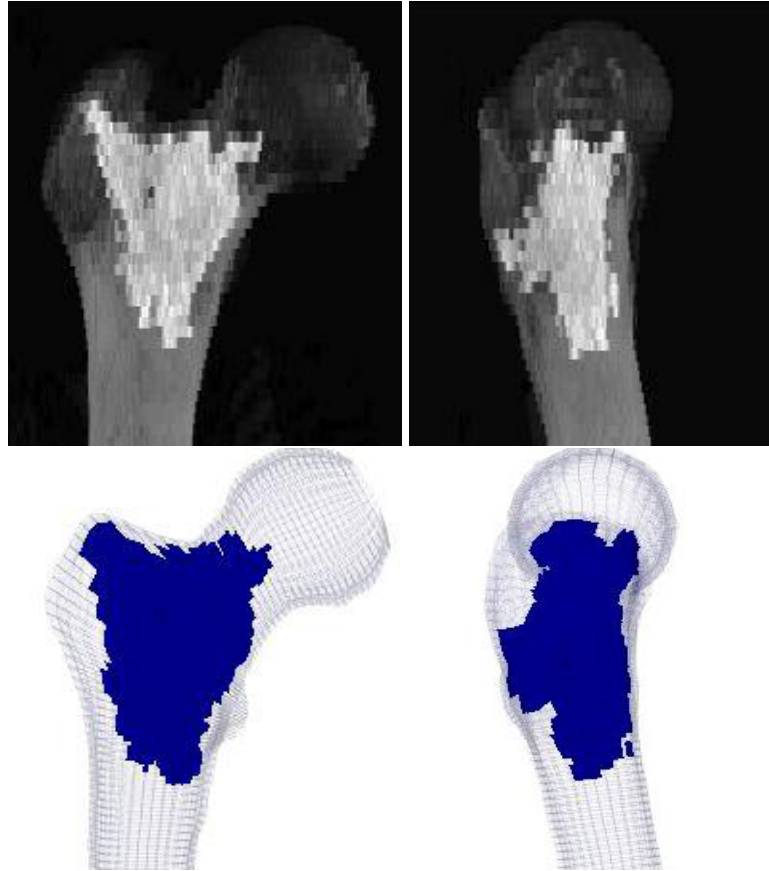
Sample cement distribution as seen in the CT projection image (top) and the corresponding cement element distribution in the FE model (bottom).
